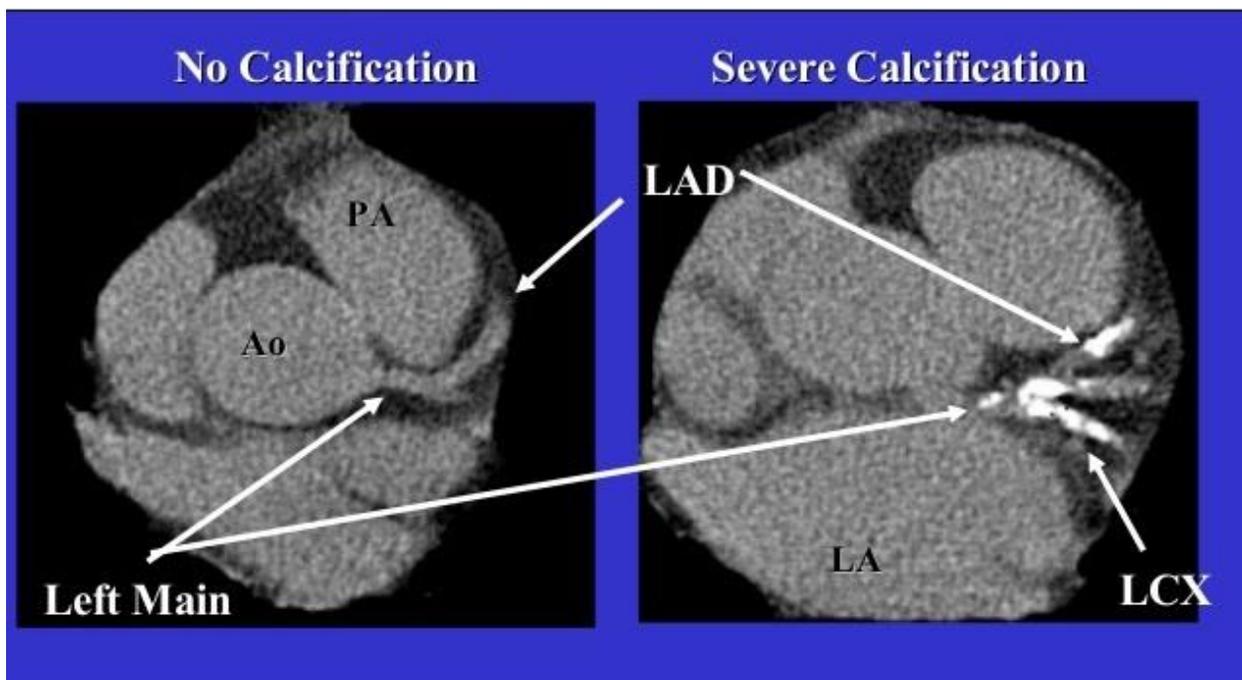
CAC and CT angiography for normal and sever calcified coronary arteries (182)
